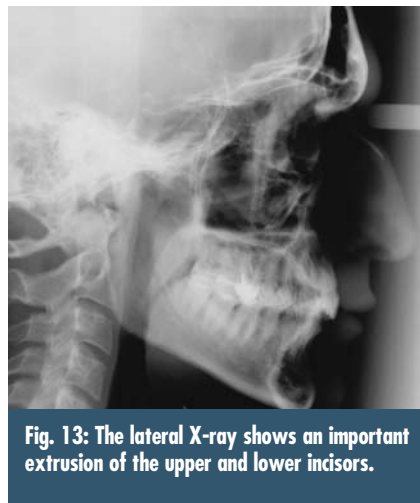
The lateral X-ray shows an important extrusion of the upper and lower incisors.
